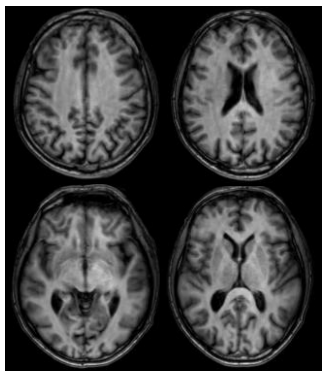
Brain MRI of patient 1.
